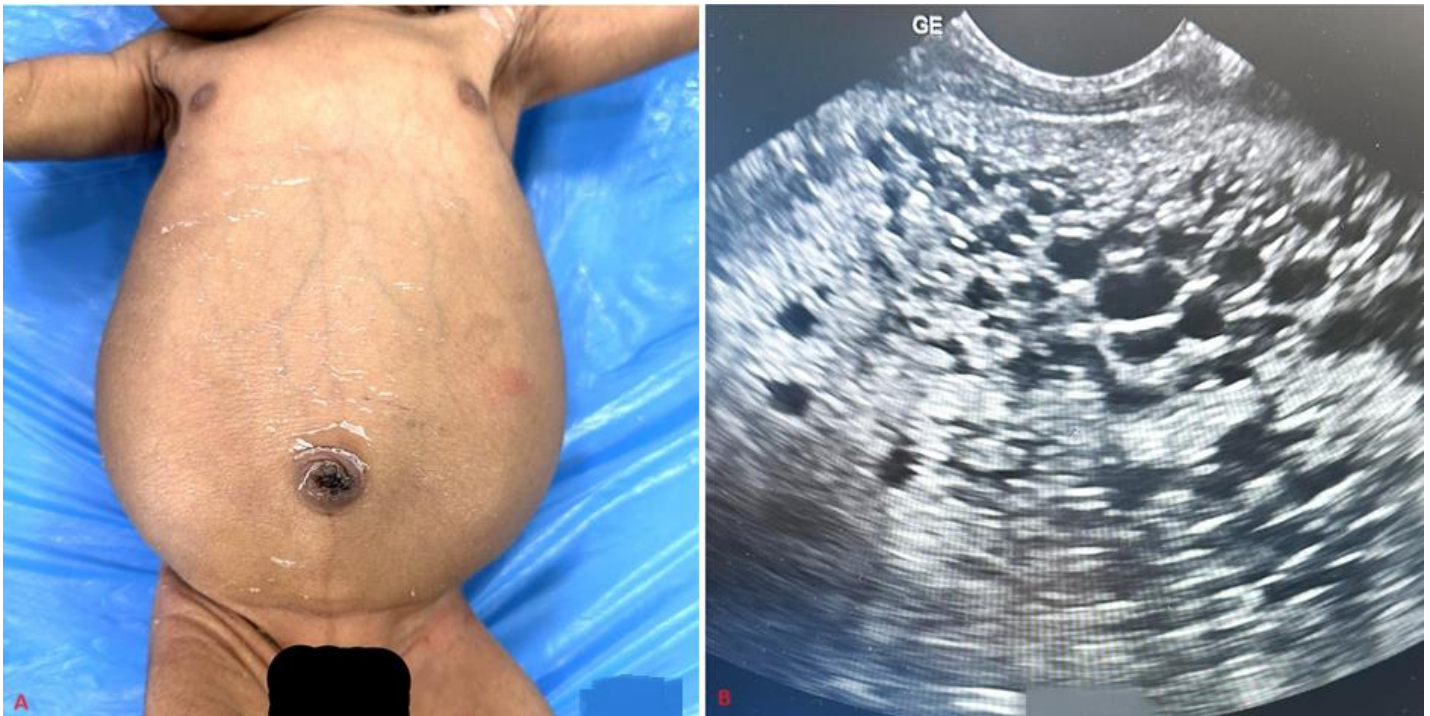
polycystic kidney disease with: A) abdominal distension; B) multiple cysts in the renal parenchyma on ultrasonography
